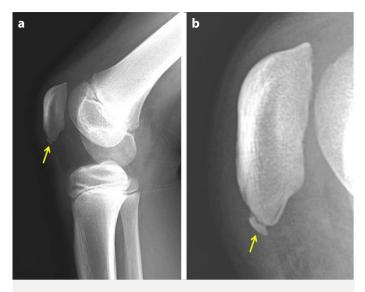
(a) Lateral knee radiograph showing fragmentation at the inferior pole of the patella (yellow arrow), characteristic of SLJS. (b) Magnified view of the inferior patellar pole highlighting the fragmented and irregular appearance (yellow arrow), consistent with apophyseal injury.
